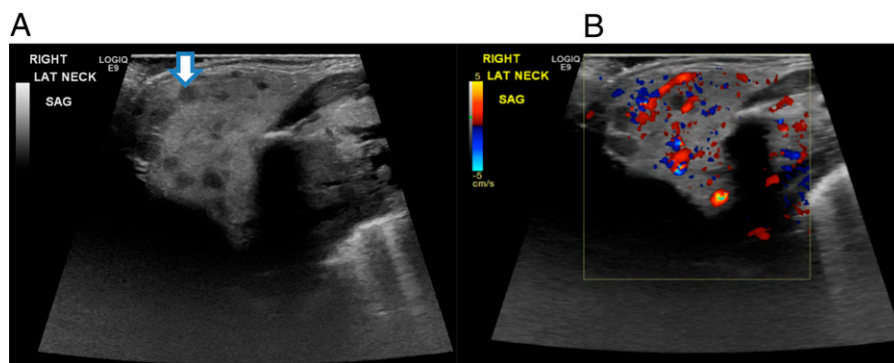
Ultrasound scan of the right side of the neck without (A) and with (B) color Doppler shows an infiltrative echogenic lesion containing multiple rounded hypodense areas (arrow). Doppler image demonstrates prominent vascular flow within the mass.
